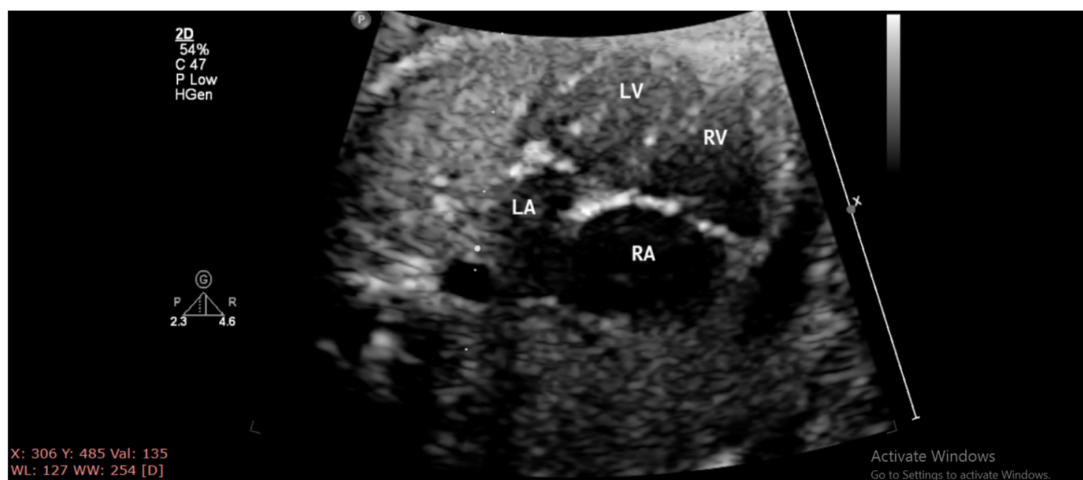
Echocardiogram on day 1 of life showing a 5 mm patent ductus arteriosus, dilated RA, RV with RV dysfunction and mild pericardial effusion
